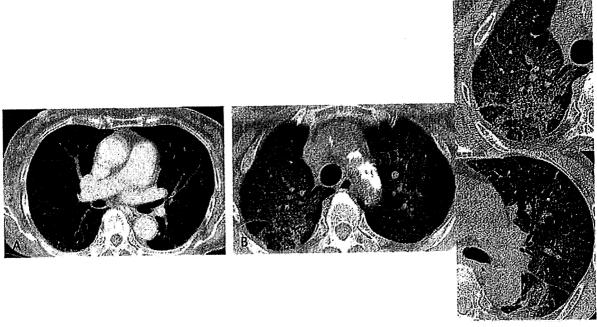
An example of CT imaging with severe pulmonary toxicity related to GEM. A, The CT imaging of patient number 8 before chemotherapy. B, The CT imagings of patient number 8 at appearance of severe pulmonary toxicity.
